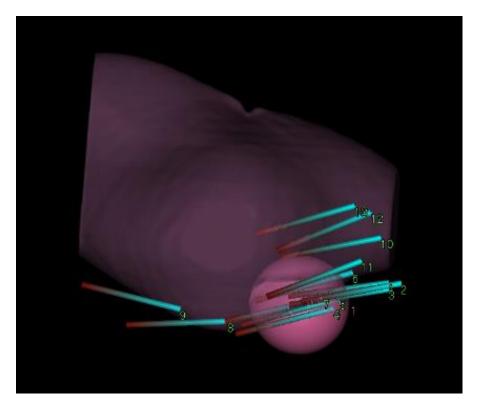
3D reconstructions of ultrasound volume dataset. Axial view.
